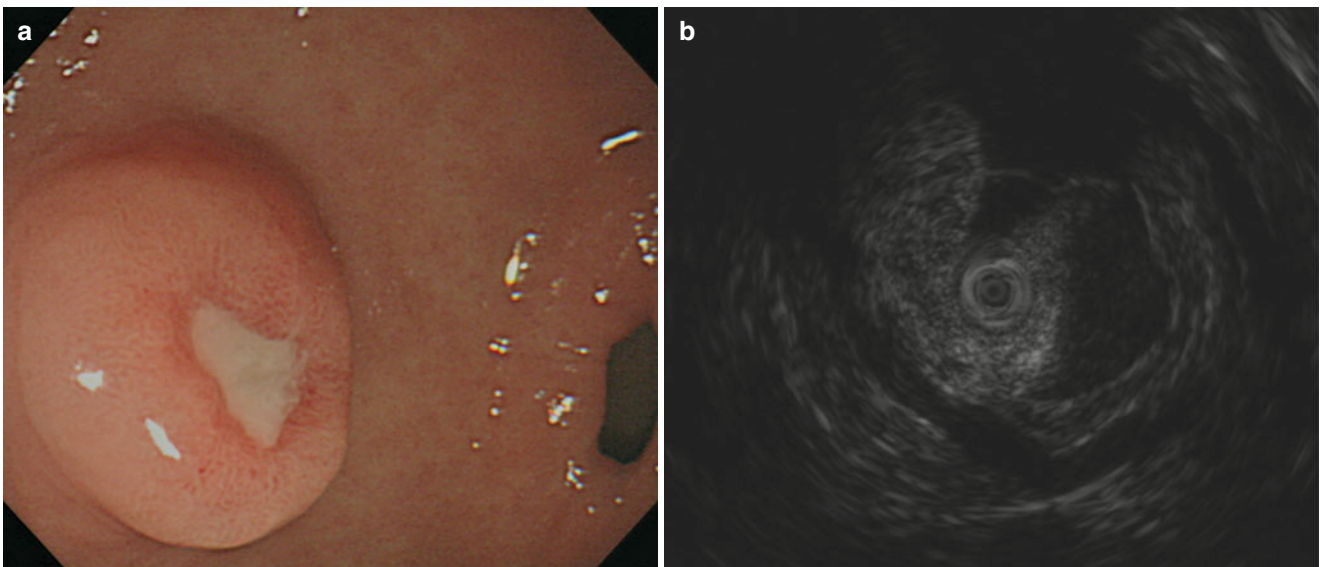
Inflammatory fibrinoid polyp. (a) Conventional endoscopy showed about 1.5-cm subepithelial tumor in the antrum of the stomach with central ulceration. (b) Endoscopic ultrasound showed a hypoechoic
